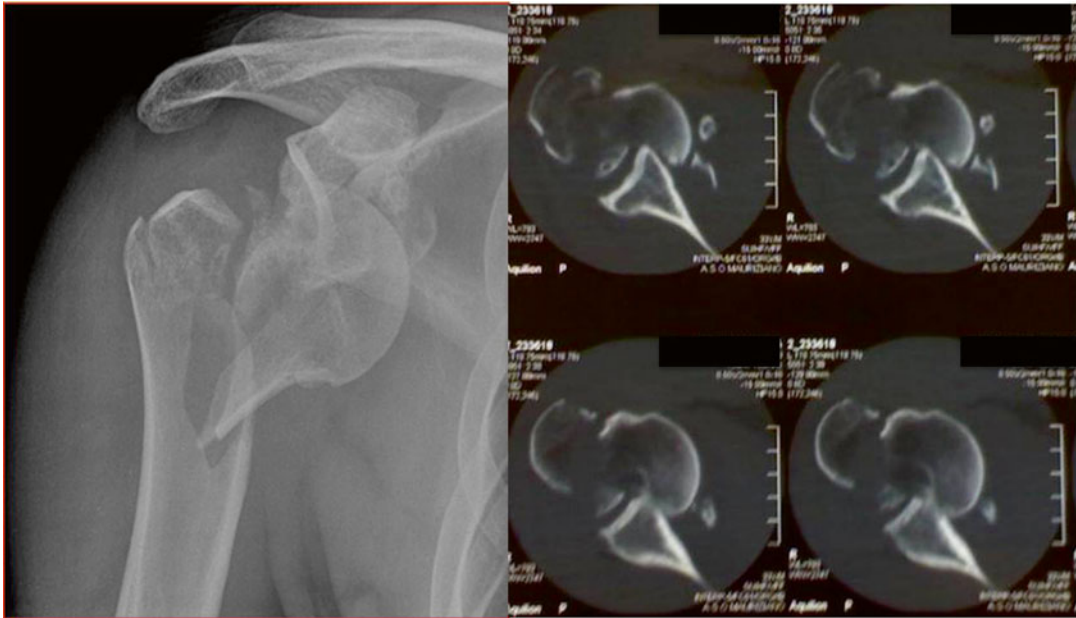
CT in case of fracture-dislocation permits to better understand the relationship among the humeral head and the medial vascular and nervous structures
